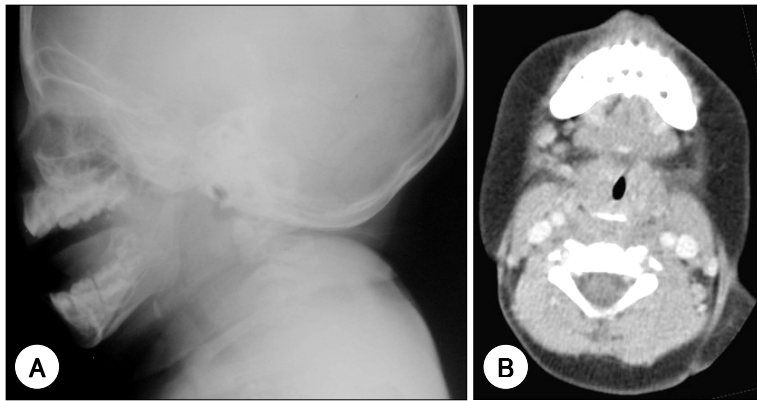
A : Lateral radiograph of the neck showing a decreased retropharyngeal emphysema. B : Computed tomographic scan shows a slit shaped high density material in the esophageal inlet. It revealed a plastic foreign body.
